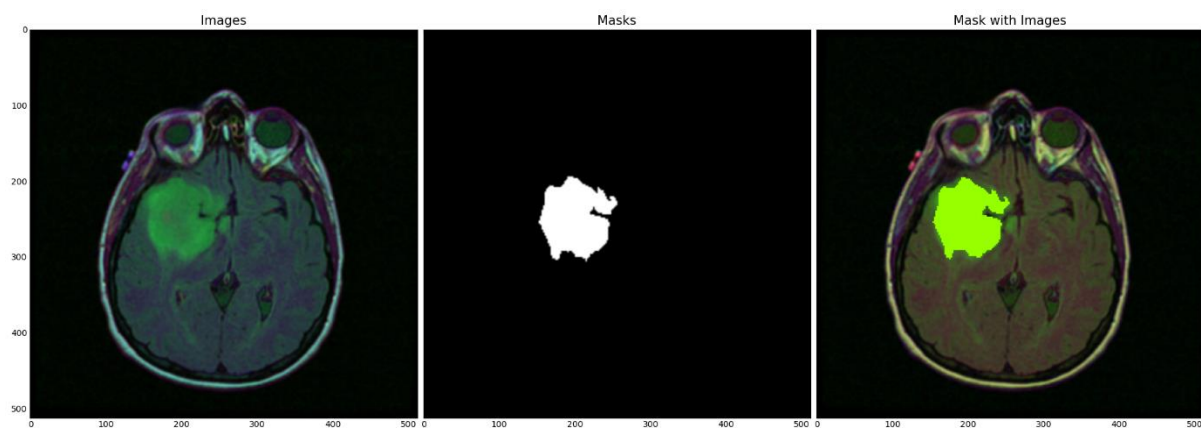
Tumor location is shown as segmented on a Brain MRI image
